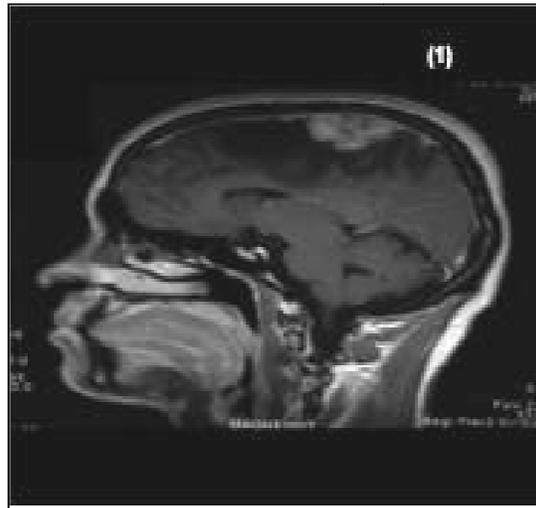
MRI (sagittal) T1-weighted after gadolinium: Before surgery irregular intra axial and parasagittal superior right lesion with perilesionnel edema
